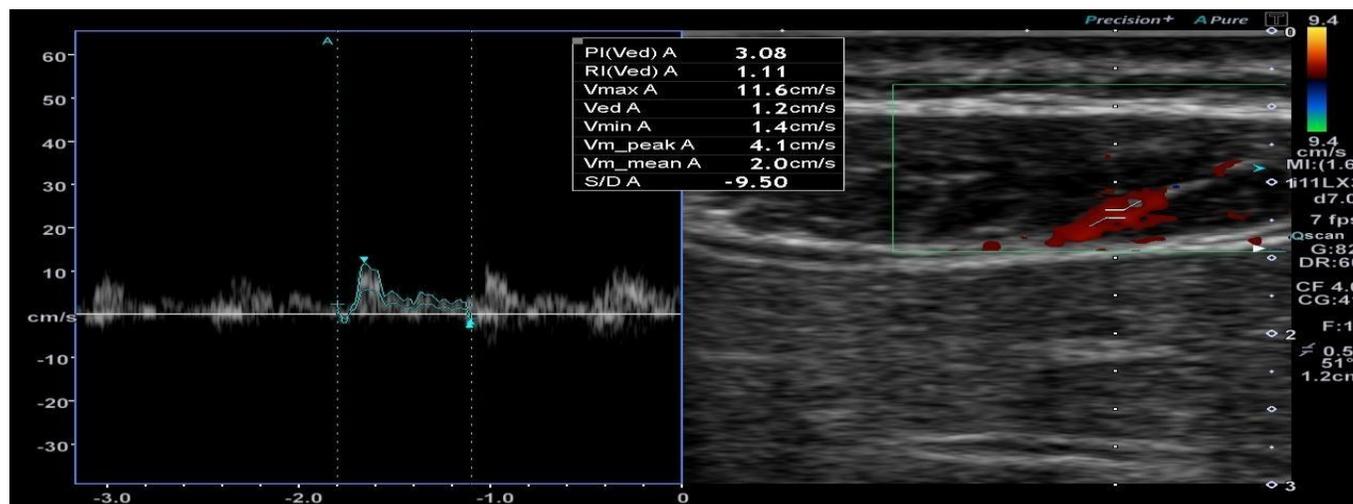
Duplex ultrasound of a perforator artery of Case 1. The waveform analysis of the artery showed a peak systolic velocity of 11.8 cm/sec, a pulsatility index of 3.08, and a resistance index of 1.11
